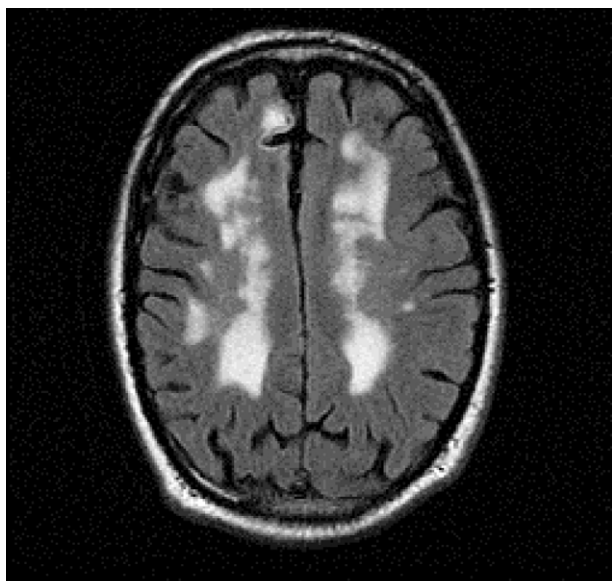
MRI scan (axial fluid-attenuated inversion recovery sequence) showing extensive white-matter lesions consistent with subcortical ischaemic vascular dementia.
